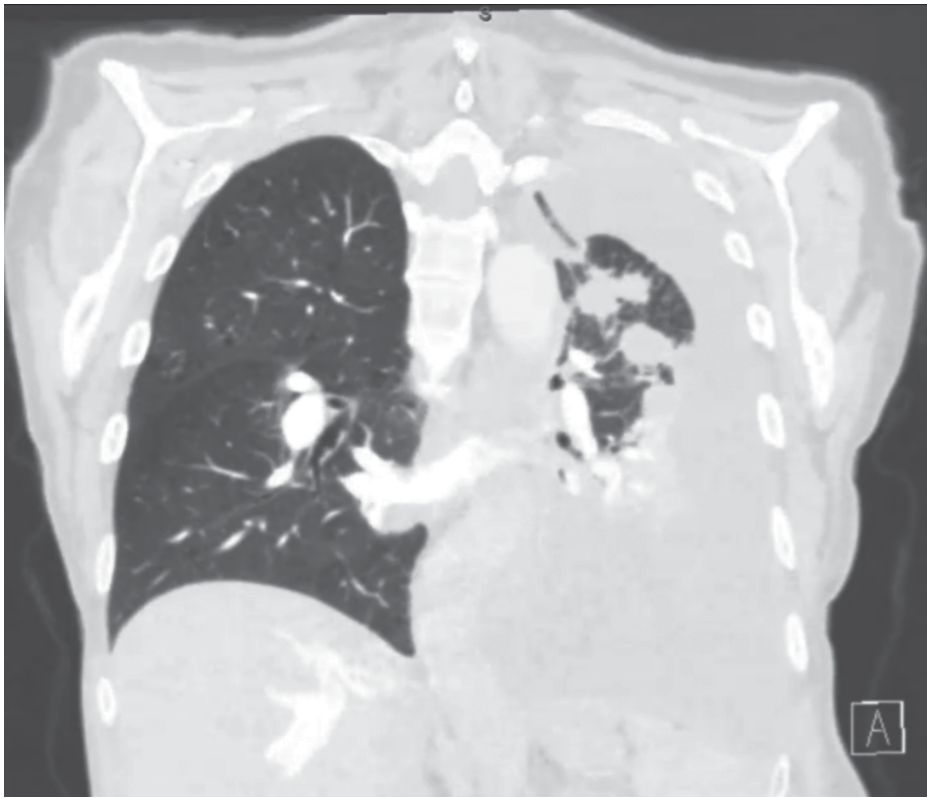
CT image demonstrating a large left pleural effusion, spiculated lung nodules, mediastinal lymphadenopathy, and liver lesions.
